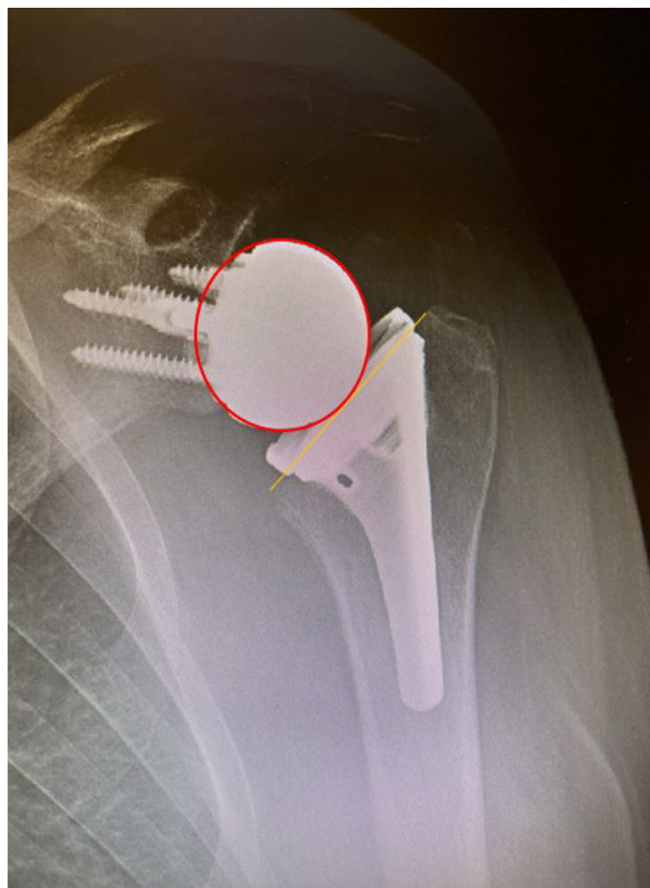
Left shoulder AP X-ray demonstrating an at-the-surface reverse total shoulder arthroplasty (DePuy Inhance; Raynham, MA, USA) with humeral tray and liner allowing for articulation at the level of the resection (yellow line).
